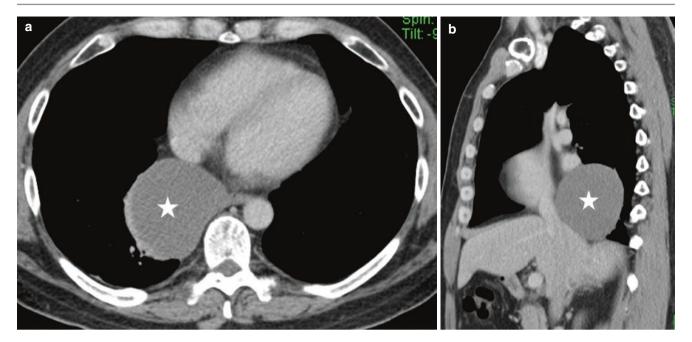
Foregut duplication cyst. (a, b) Axial and sagittal CT images reveal a homogenous well-defined cystic posterior mediastinal mass in close proximity to the lower esophagus (asterisk)
